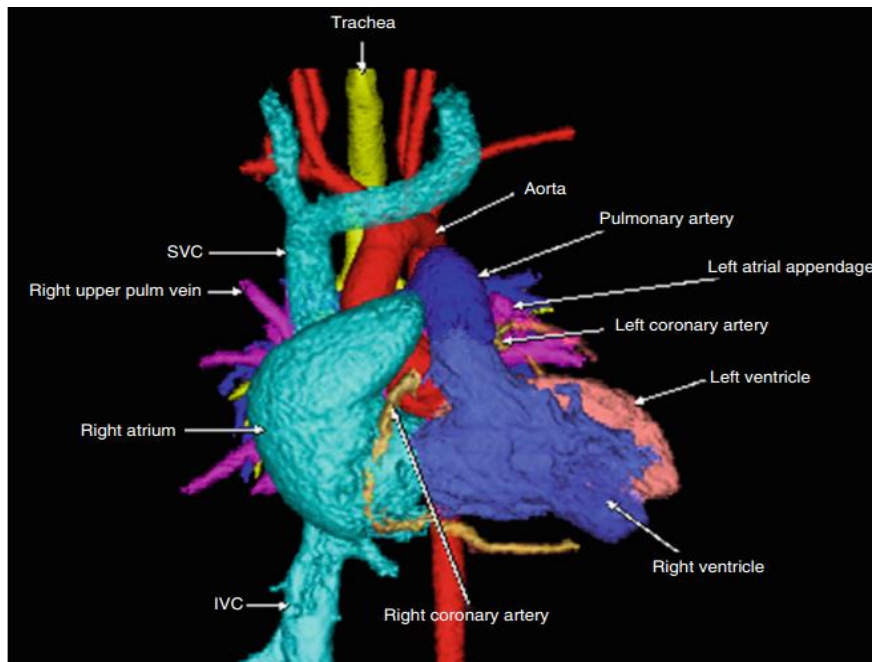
Full color-coded 3D CT model reveals cardiac anatomy (*Quoted from Richardson, 2013*).
